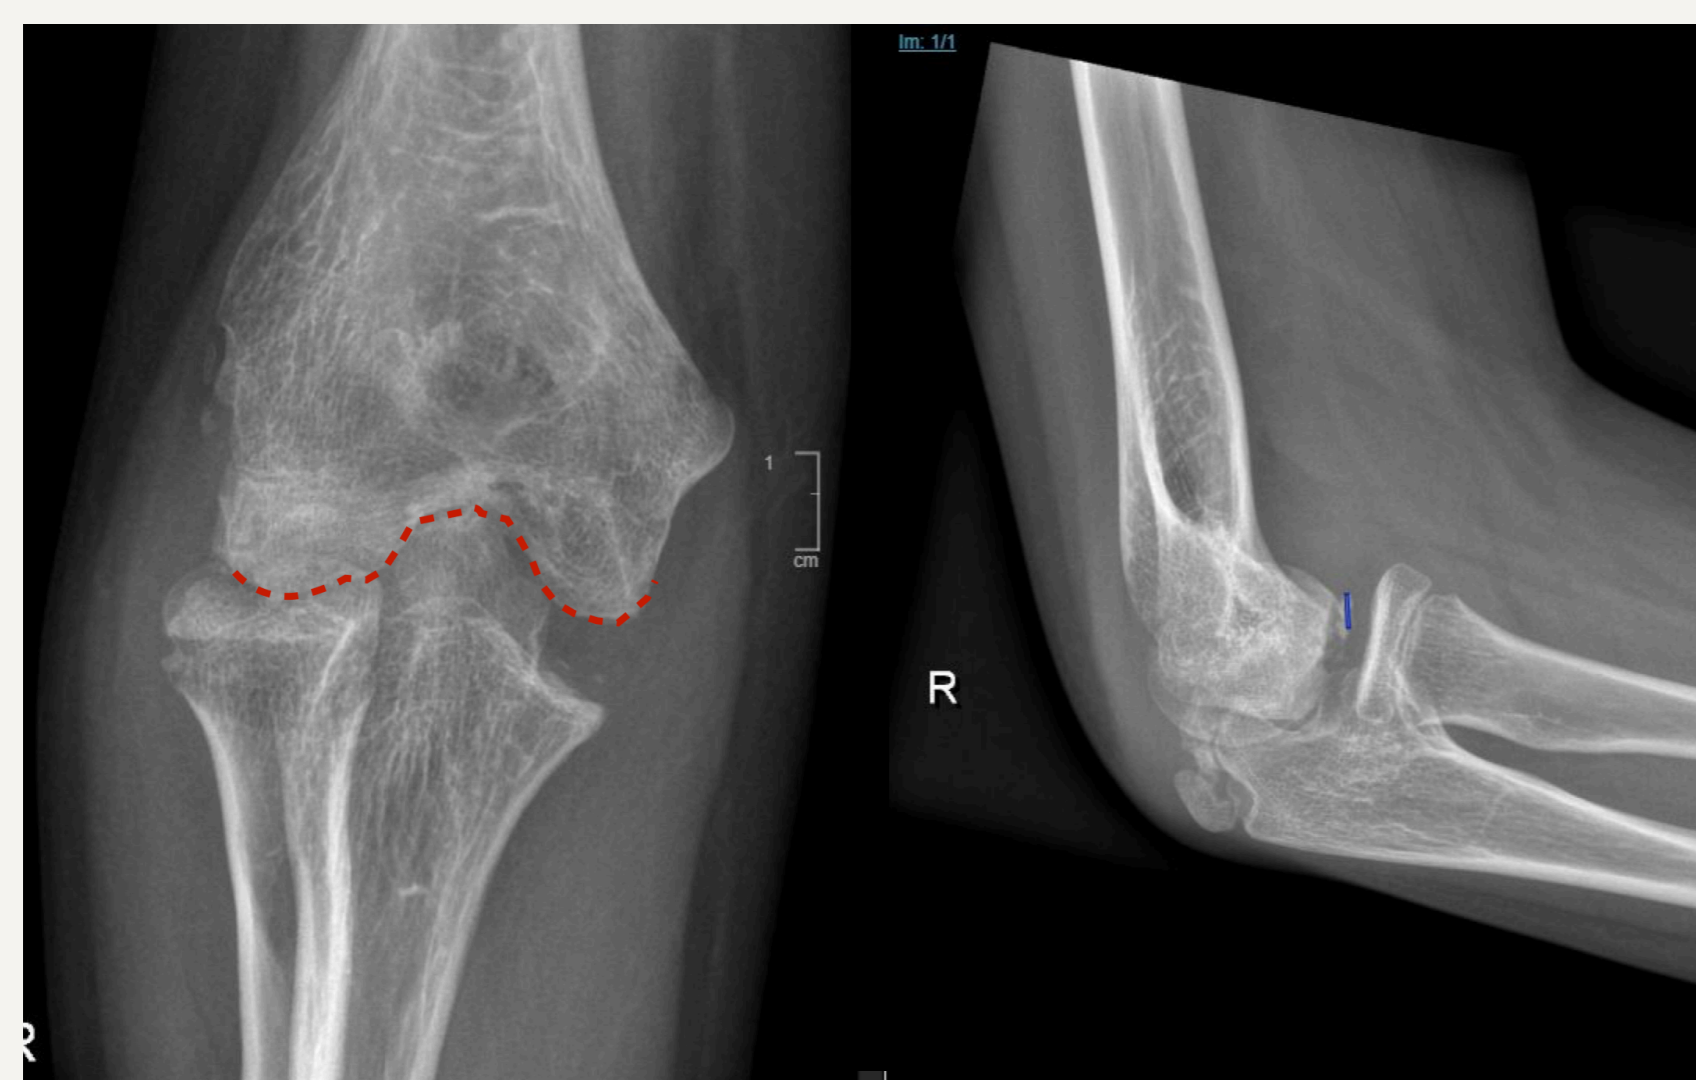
ap/lateral radiograph, deformity of the humeral trochlea involving the trochlear groove, "fishtail deformity" (red line), loose bodies lying anterior to the humeral capitulum, subluxation of the radial head, fat pad sign
